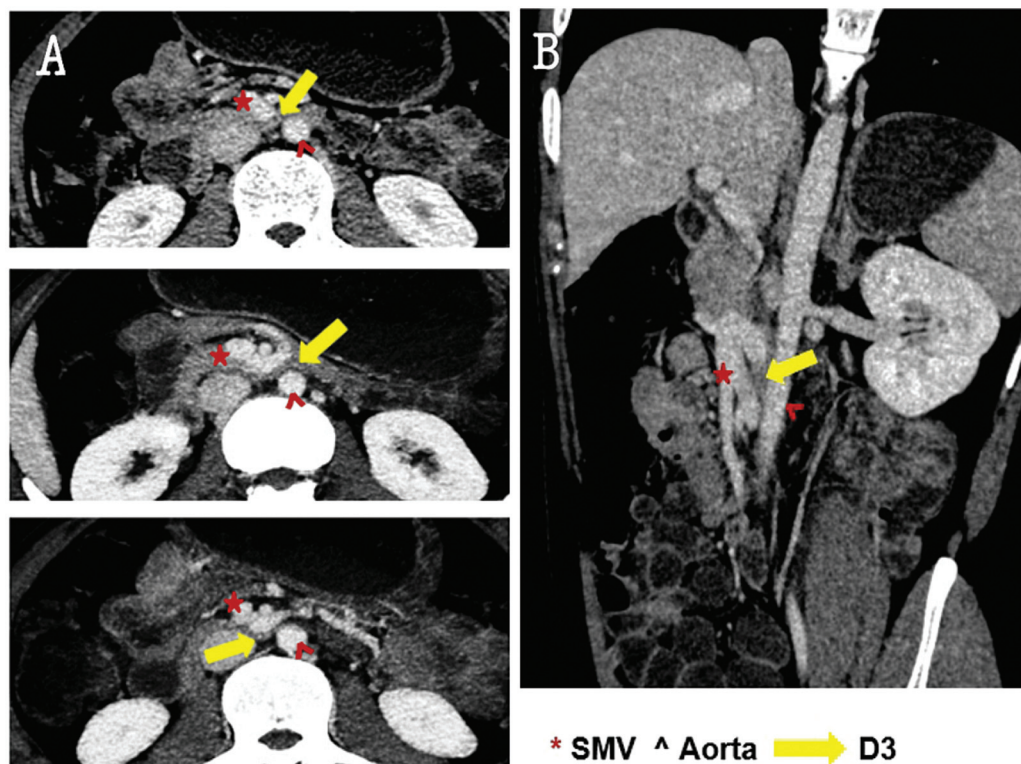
(A) CECT-ABD (venous phase) axial sections at the level of D3 segment. (B) CECT-ABD (venous phase) oblique coronal section showing SMV and its tributaries. CECT ABD, contrast-enhanced computed tomography abdomen; SMV, superior mesenteric vein.
